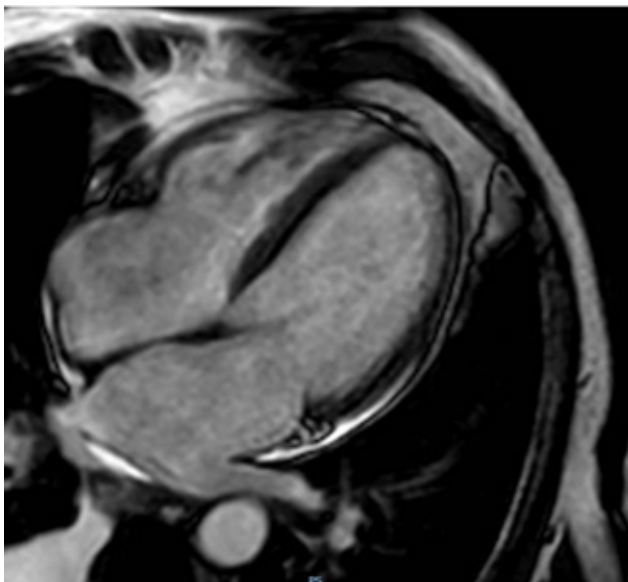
Magnetic resonance imaging of the heart showing the presence of delayed mesocardial myocardial enhancement in the middle and basal anteroseptal and inferoseptal segments, compatible with myocarditis.
